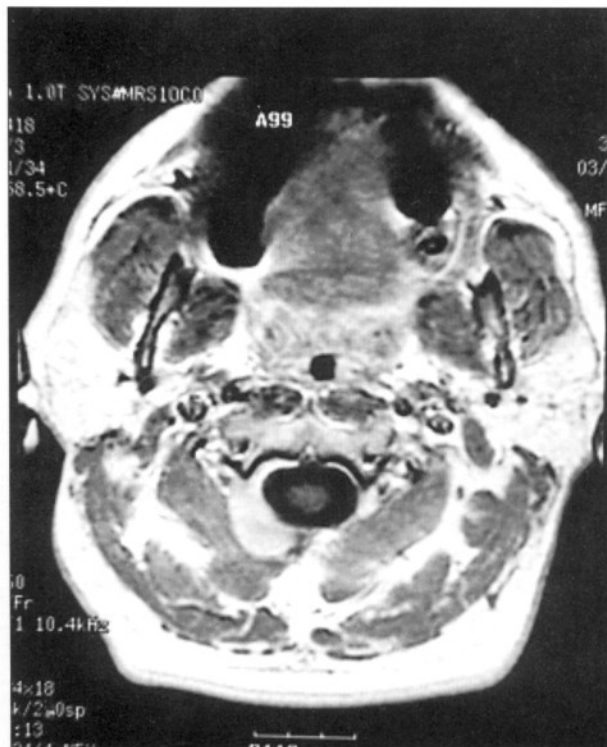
Contrast-enhanced axial T1-weighted MRI at 3 months after surgery at C5-6 and C6-7 demonstrates enlargement of the C2 mass.
